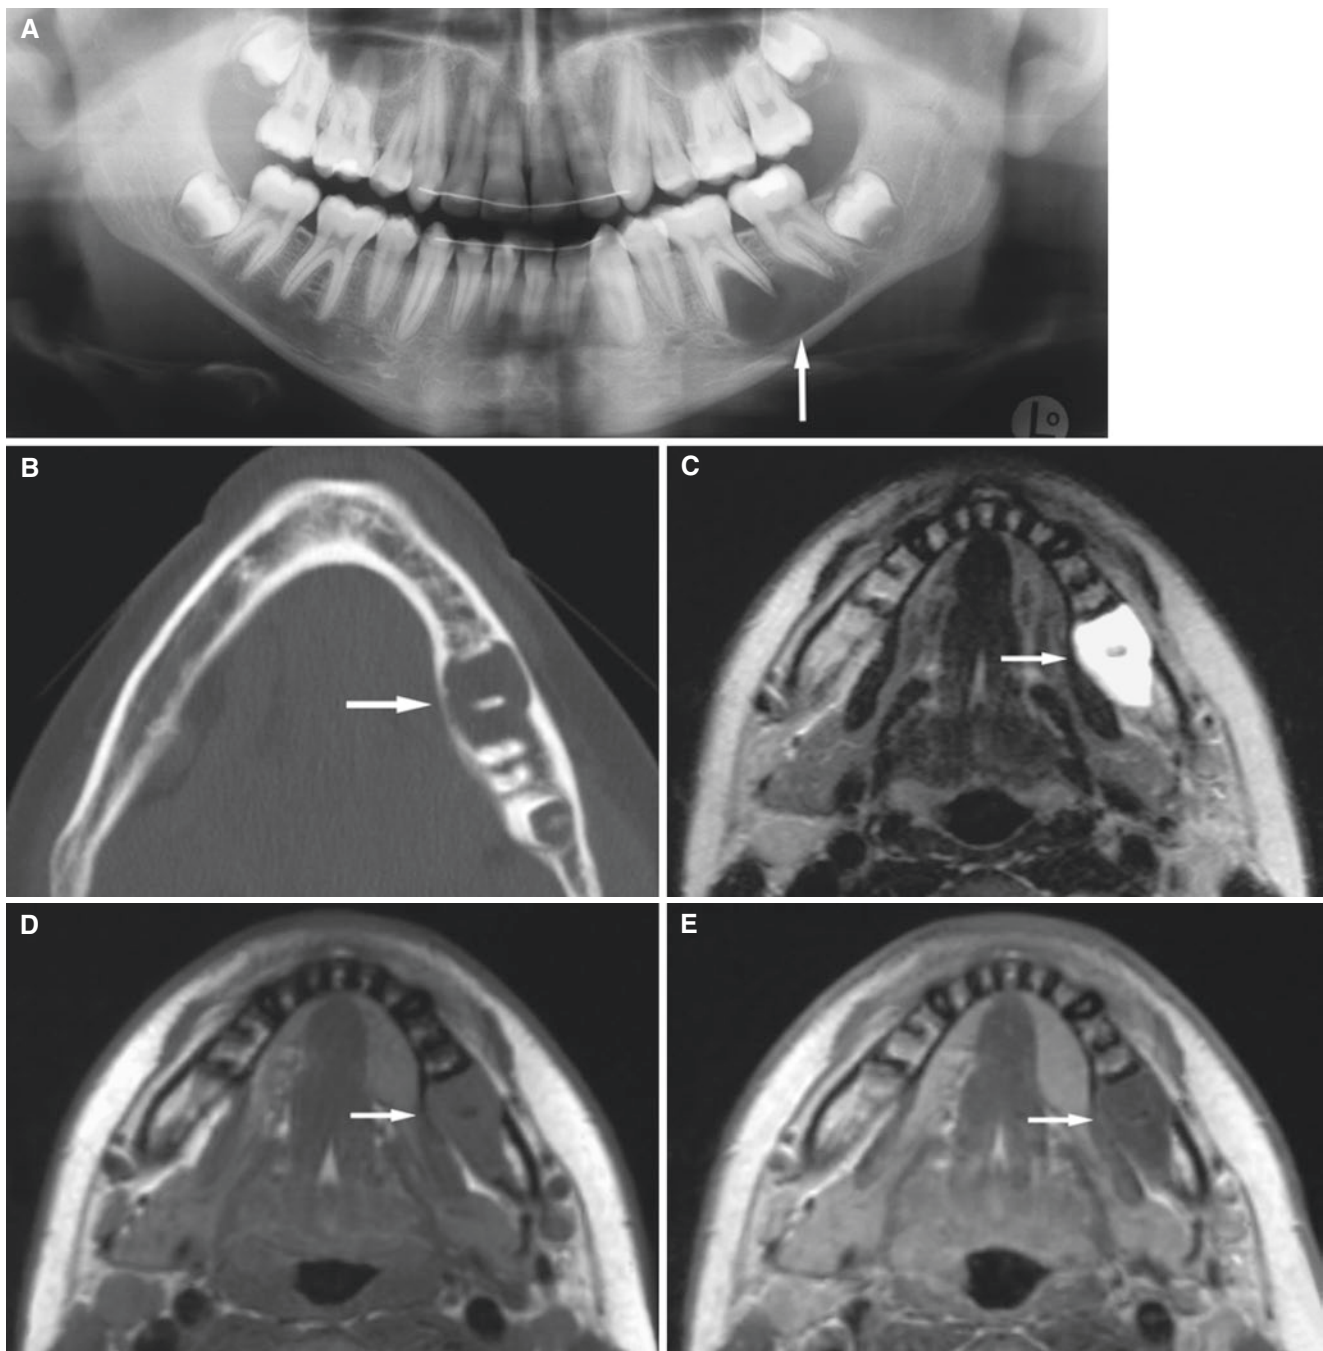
Simple bone cyst, mandible; 15-year-old male with incidental finding at routine dental radiography. (A) Panoramic view shows well-defined radiolucency with no sclerotic border (*arrow*). (B) Axial CT image shows expanded, thinned, and intact cortical bone (*arrow*).
